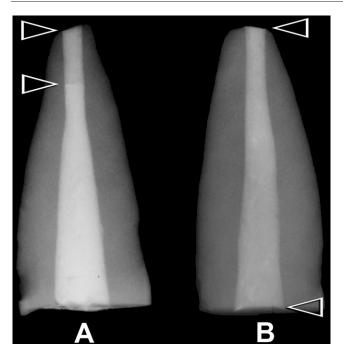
Radiographs of root segments with artificially created open apices that were closed with (*A*) An orthograde, 3- to 5-mm-long white MTA apical plug, followed by backfilling with gutta percha only without the use of a root canal sealer. (*B*) An orthograde white MTA root canal filling that extended from the open apex to the root canal orifice. The root canal space between the open arrowheads in each respective root segment represents the region occupied by the white MTA in this one-visit apexification model.
